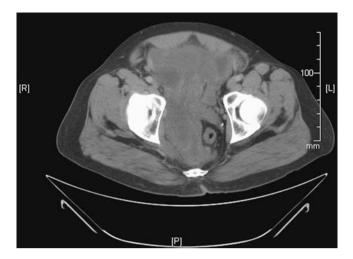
Axial contrast enhanced CT image of a recurrent pelvic angiomyxoma
